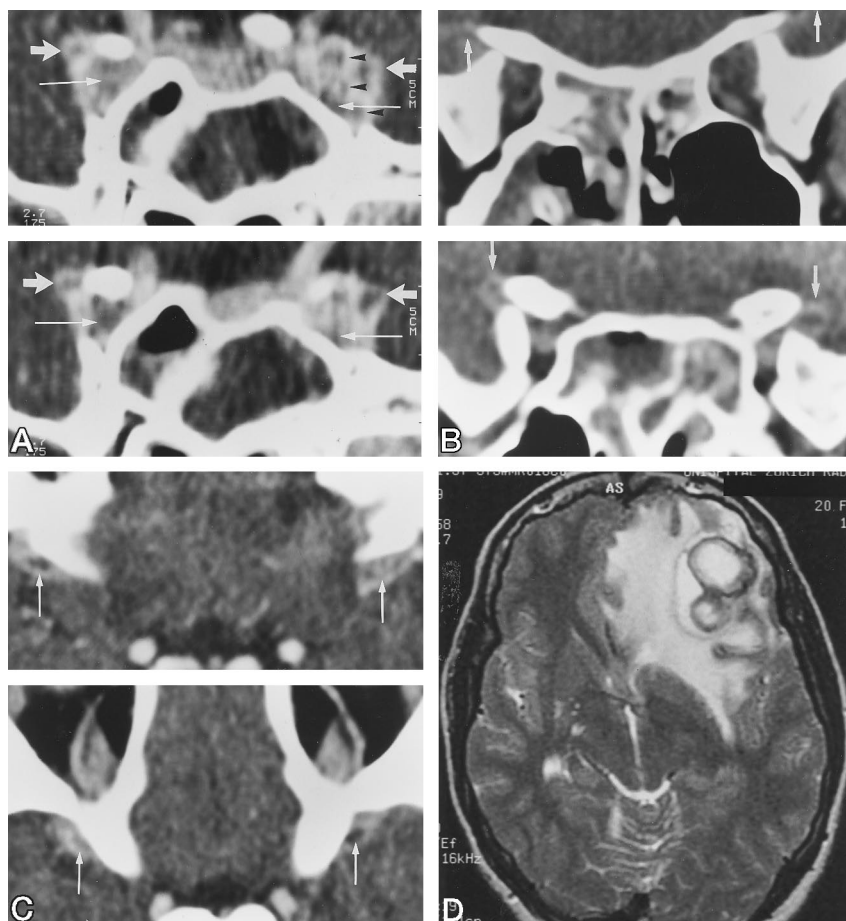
A, Coronal contrast-enhanced CT scan through middle and anterior cavernous sinus shows filling defects expanding cavernous sinus (long arrows) and sphenoparietal sinus (short arrows) bilaterally (arrowheads correspond to cranial nerves).
